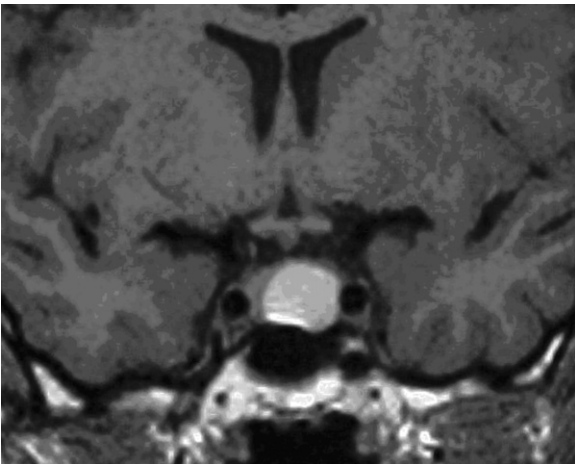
Sellar region magnetic resonance imaging showing a rounded area of increased signal on T₁-weighted sequences in the left portion of the hypophysis related to intraparenchymal hemorrhage. (Courtesy of Professor Stefano Bastianello.)
